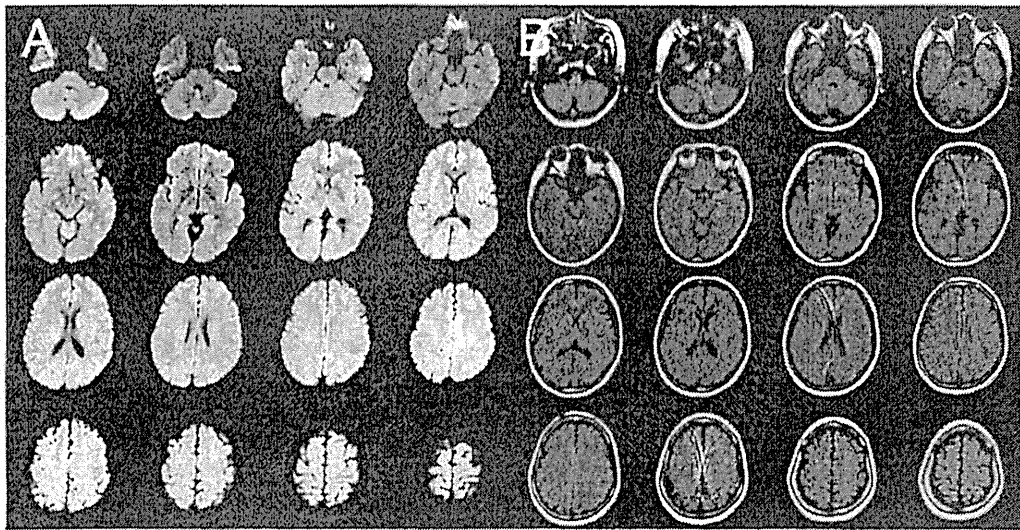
入院時MRI (A: 拡散強調画像, B: FLAIR 画像)
